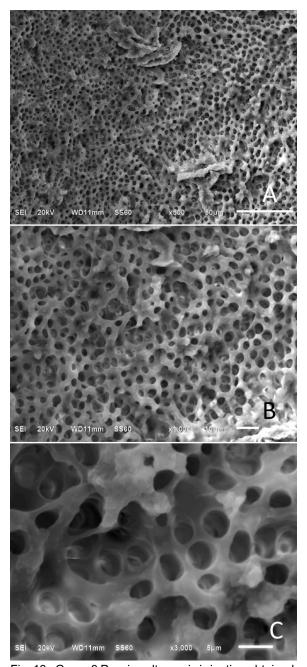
Group 3 Passive ultrasonic irrigation obtained an average on the scale of 2 which corresponds to small, scattered amounts of mud and open dentinal tubules at apical third. A) microphotography at 500x, B) microphotography at 1000x, and C) microphotography at 3000x.
